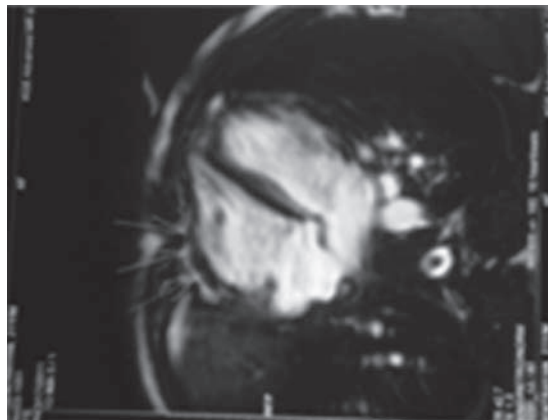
Cardiac magnetic resonance imaging showing dysplastic right ventricular and diastolic outbulging.
